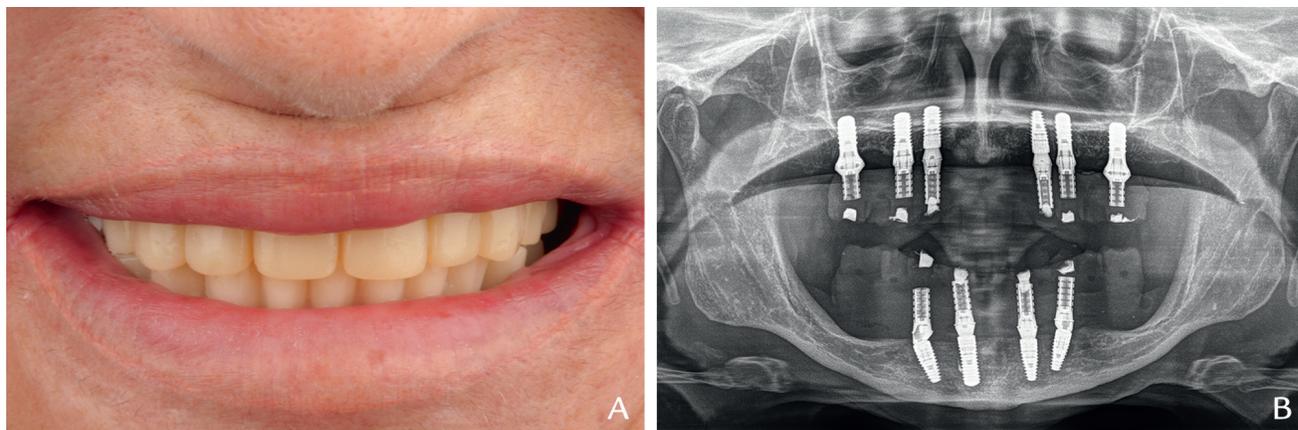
Interim restorations. A, Smile view. B, Panoramic radiograph.
